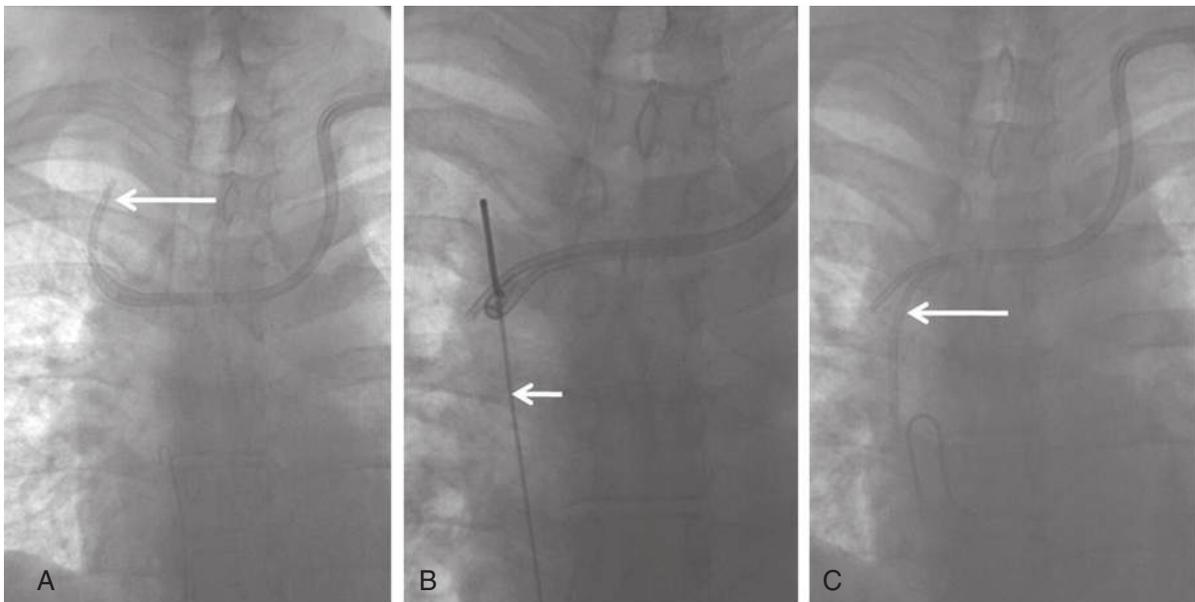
Secondary malposition into the contralateral brachiocephalic vein in a 38-year-old man on hemodialysis. Chest radiograph (A) demonstrated the tips (arrow) of the left dialysis lines had spontaneously migrated into the right brachiocephalic vein. Fluoroscopy image (B) showed the use of a Sidewinder catheter (arrow) to pull the lines down into the superior vena cava (SVC). Postintervention image (C) showed satisfactory repositioning of the lines (arrow). (From Nayeemuddin M, Pherwani AD, Asquith JR. Imaging and management of complications of central venous catheters. *Clin Radiol*. 2013;68[5]:529–544.)
